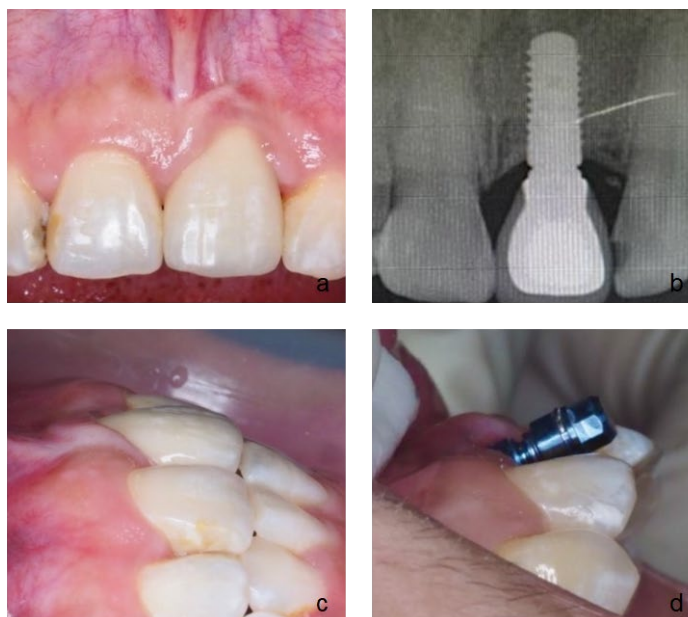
Pre-treatment clinical characteristics: (a) Mid-labial mucosal recession of implant-supported crown 21 with thin mucosal phenotype, and intact interdental papilla. (b) Periapical radiograph of Straumann bone level implant (D:4 mm x L:10 mm). (c) Emerge profile of the crown with labial depression. (d) Lateral view showing implant angulation post- crown removal.
